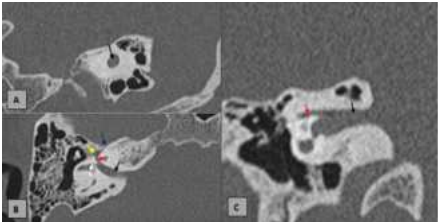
HRCT temporal bone algorithm; A. sagittal; B. axial at the level of upper compartment of IAC and C. coronal sections, showing IAC (black arrow), canal for labyrinthine segment of facial nerve (red arrow) and superior vestibular nerve (white arrow). The greater superficial petrosal nerve is seen arising from the geniculate ganglion
